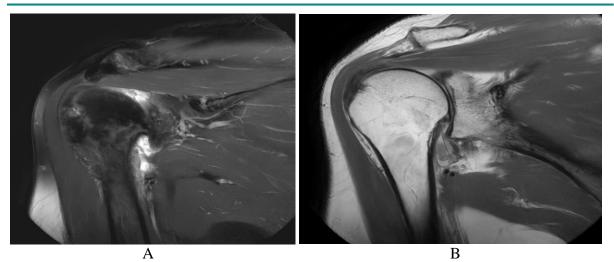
(A, B): MRI of Right shoulder joint showing evidence of tendinopathy, increased signal subscapularis and supraspinatus with moderate to large effusion
